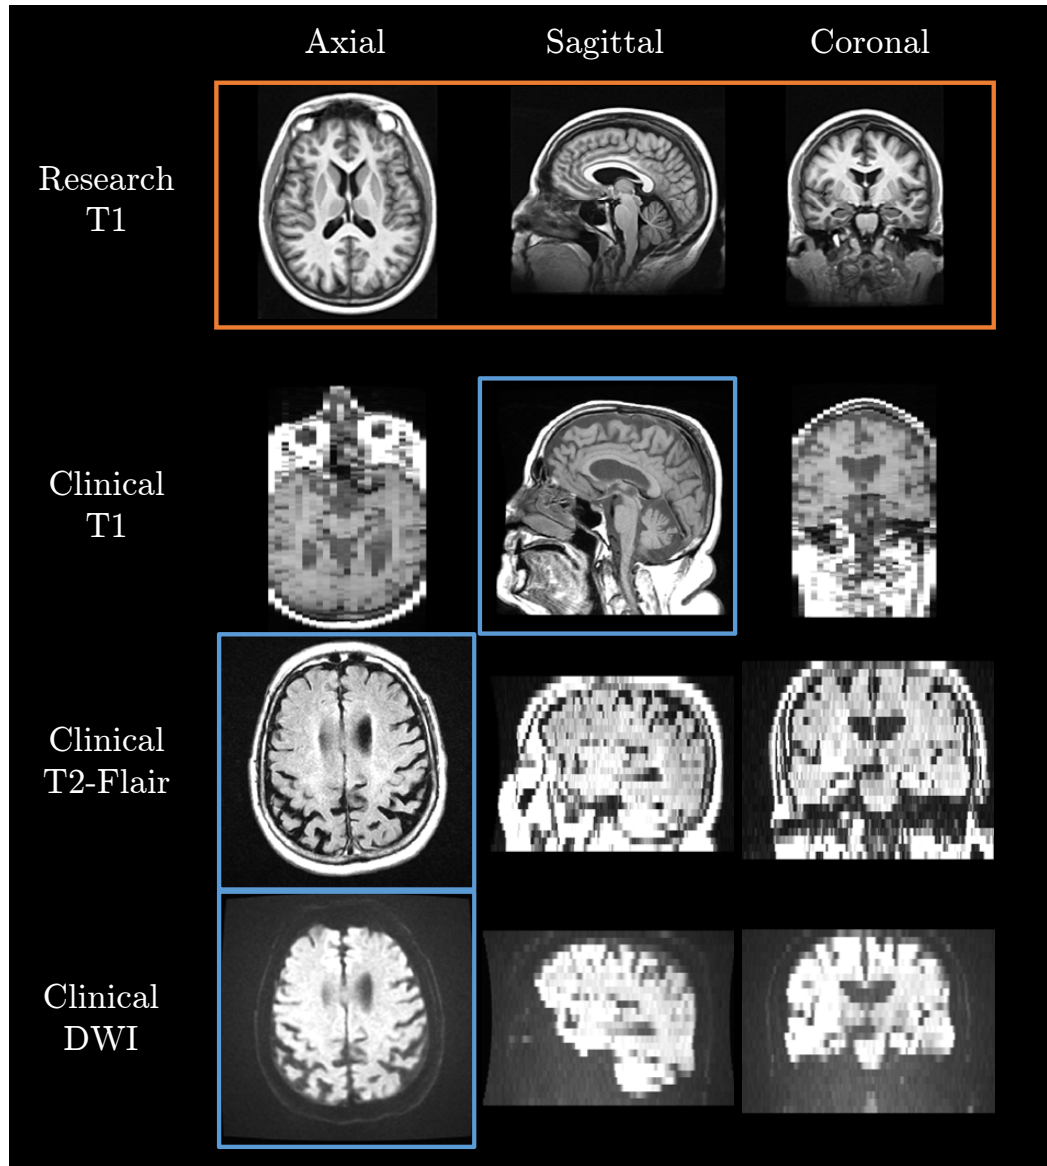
Example clinical images. Top row (orange box): research high resolution scan. Next three rows: images from a patient in the stroke study: T1 (top), T2-FLAIR (middle), and DWI (bottom). Three orthogonal slices are shown for each modality; in plane slices are highlighted in blue. Note the large slice thickness in clinical scans.
